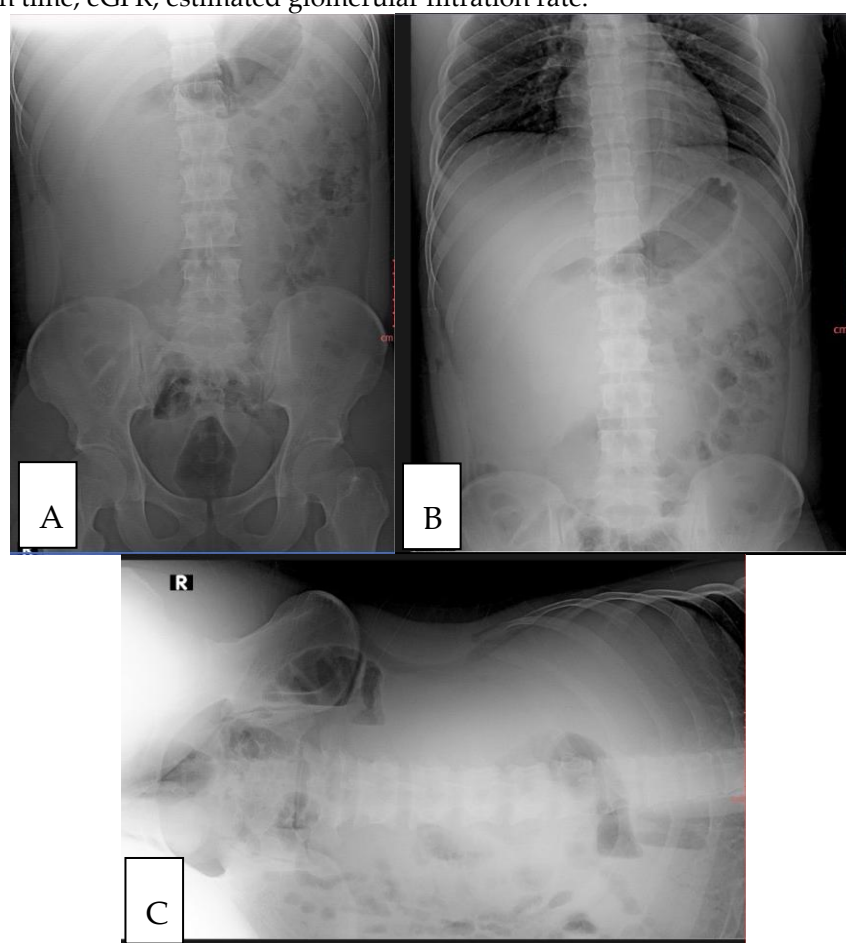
Preoperative abdominal Xray on (A) supine, (B) erect view, (C) and left lateral decubitus view showed no free intraperitoneal air or fluid and no bowel dilation, but demonstrated a well-defined oval intraperitoneal opacity in the right hemiabdomen displacing bowel gas into the left hemiabdomen.
